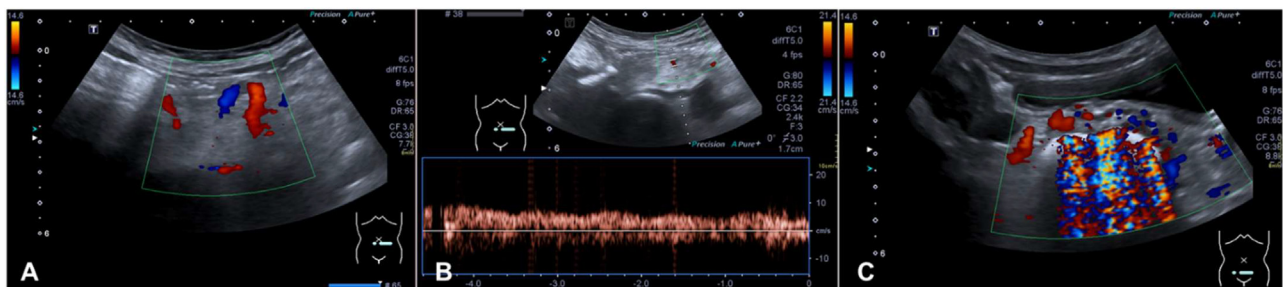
Doppler ultrasound images in the transverse plane of the mesogastrium (A and B) and hypogastrium (C) in color and spectral Doppler mode show the tortuous and dilated inferior mesenteric vein communicating with the rectal venous plexus.
